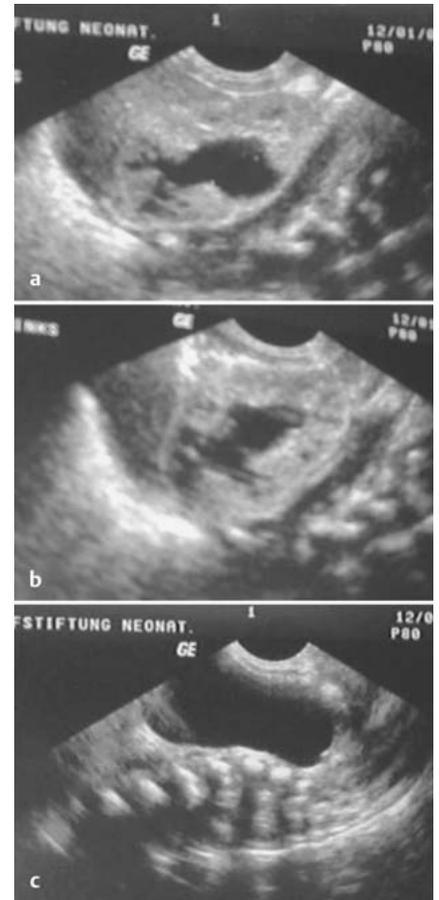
a to c Distended bladder (a) and renal pelvis (b left kidney, c right kidney) on ultrasound.
